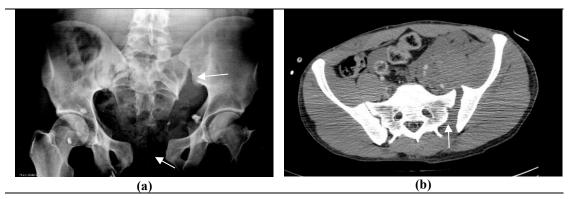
Dismounted Case Study 1. Pelvic film (a) demonstrating disruption at the left sacroiliac joint and pubic symphysis and axial CT scan (with binder now placed) demonstrating the left sacroiliac joint separation.
